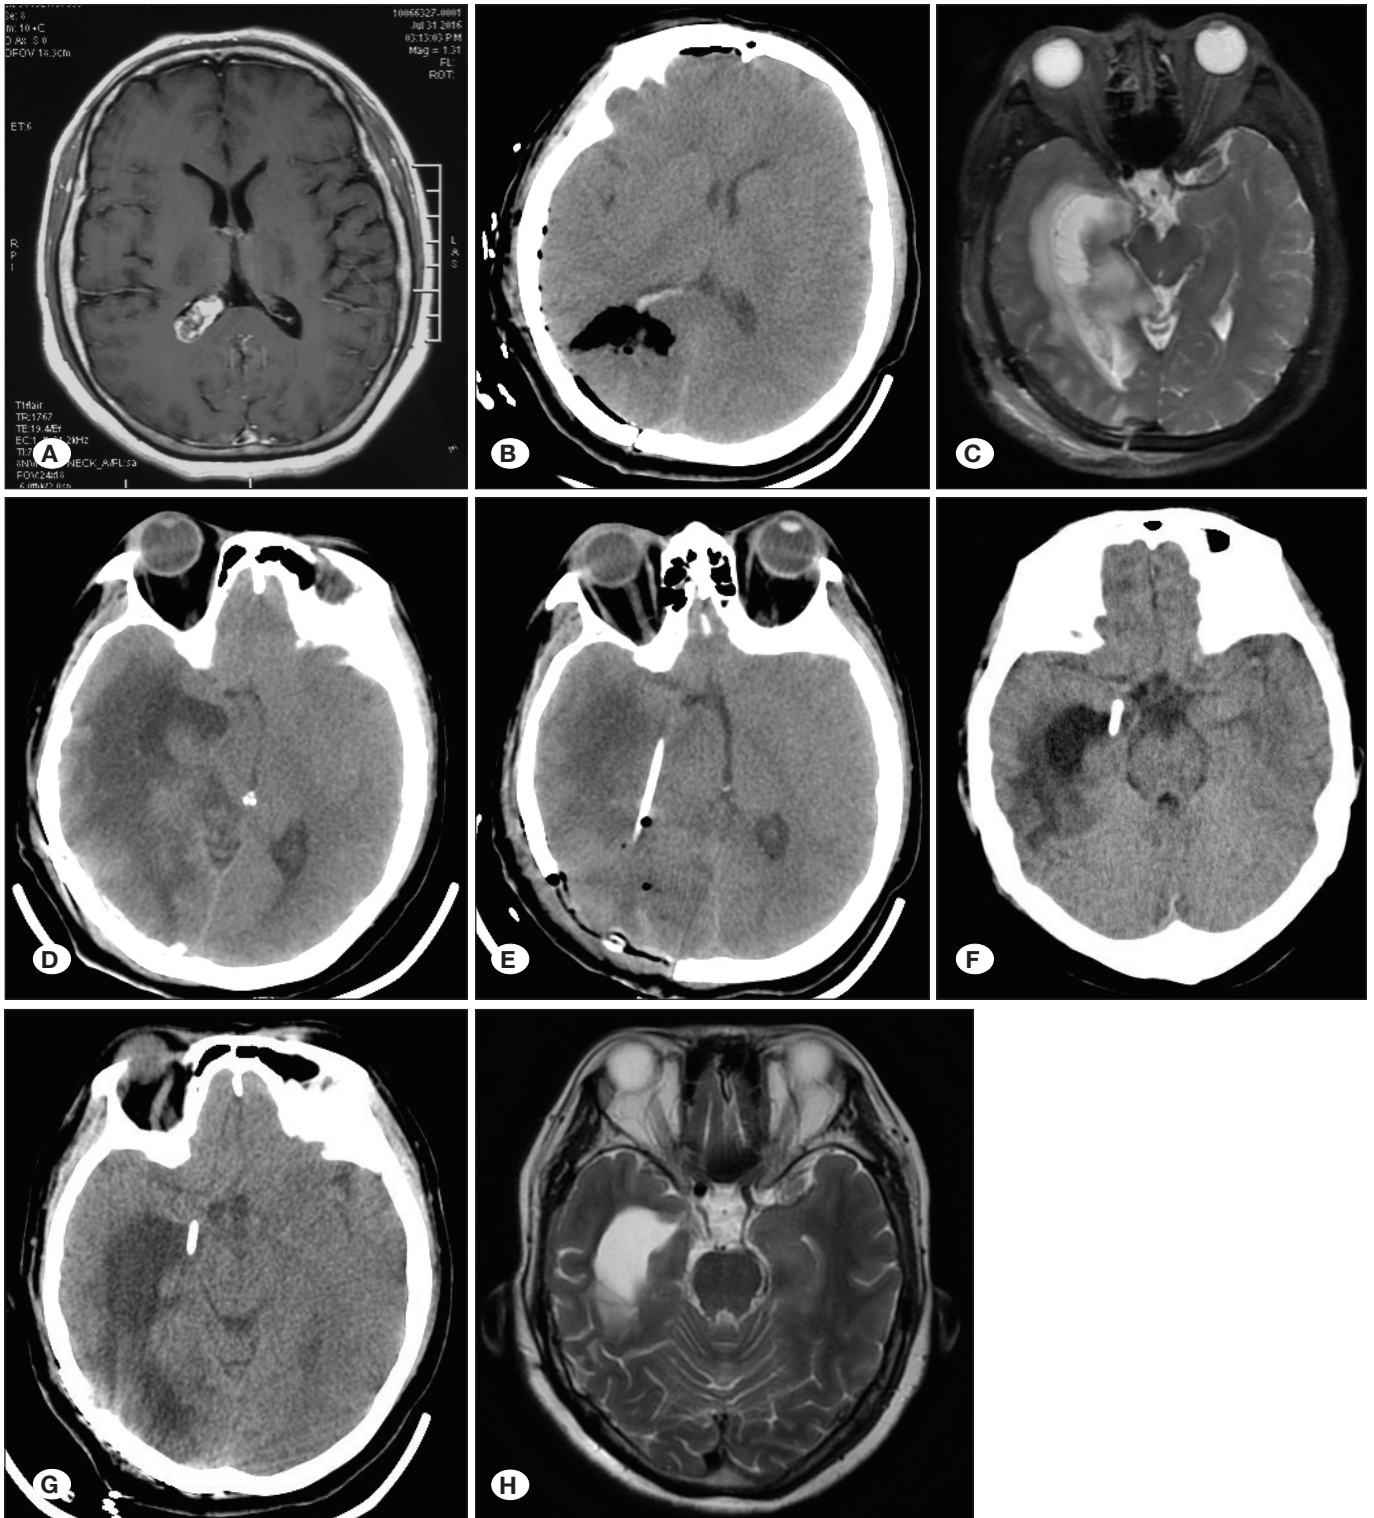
A) Preoperative MRI. B) CT re-examination on the day following operation. C) MRI re-examination on postoperative day 3. D) CT re-examination on postoperative day 6. E) CT re-examination on the similar day following intraventricular drainage. F) The dynamic reexamination of CT following drainage tube implantation. G) CT re-examination 6 months following discharge. H) MRI re-examination 1 ½ years following discharge.
